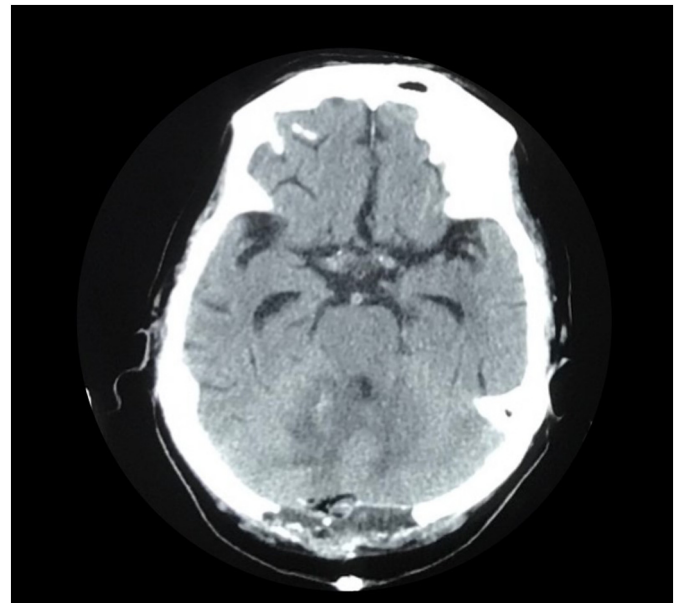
Postoperative CT demonstrated hematoma was well removed.
